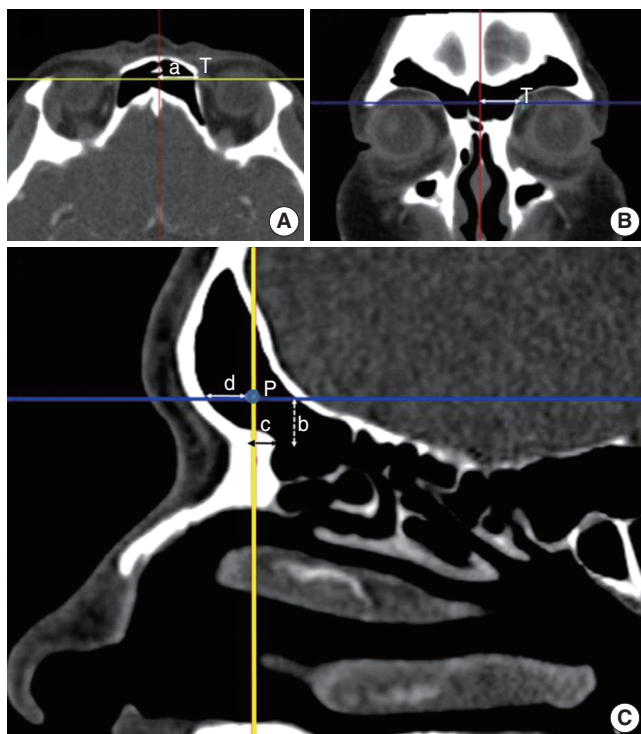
Multiplanar reconstruction of the computed tomography scan and measurements regarding the trochlea of the SO. To evaluate the relationship between the surrounding structures and the trochlea, the coronal, axial, and parasagittal planes were observed. The red line and yellow line in the axial plane meant the position of the sagittal plane and coronal plane separately and the blue line in the coronal plane meant the level of the axial plane. The distance (a) was the horizontal distance between the midline and trochlea and well identified in axial (A) and coronal (B) planes. In the parasagittal plane (C) that was located at the midpoint of the frontal sinus opening, an imaginary point (P) that was parallel to the trochlea in position and level was drawn. The distance (b) was the vertical distance from P to the frontal beak. The distances (c) and (d) were the anteroposterior distances from P to the anterior frontal sinus wall and frontal beak, separately. SO, superior oblique muscle; T, trochlea.
